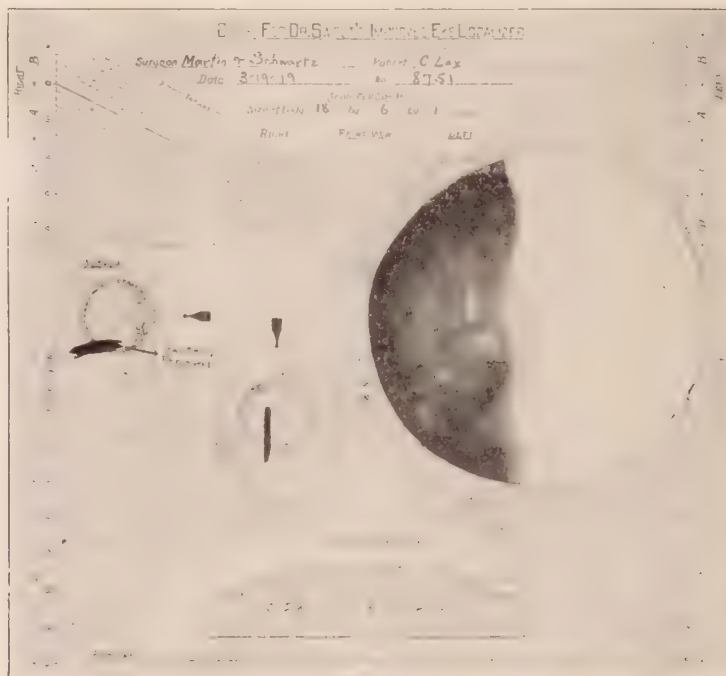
C. L., injured in right eye March 17, 1919. Incised wound of lower lid, with soft tissues edematous; cornea and anterior chamber uninjured; lens clear; fundus clear in upper portion; large dark mass in floor of vitreous; vision in lower field only. X-ray showed a very large, thin foreign body localizing part way within the vitreous chamber and protruding posteriorly beyond the globe. By giant magnet, this was drawn back through wound of entrance. On April 7 he was discharged with eye of good appearance and with vision of fingers at three feet. Comment.—It is extraordinary to have so large a foreign body penetrate the globe and yet to preserve the globe after its removal. It was very thin and its shape and position, as shown by the localization, enabled the surgeon to withdraw it with the magnet with a minimum of trauma.
